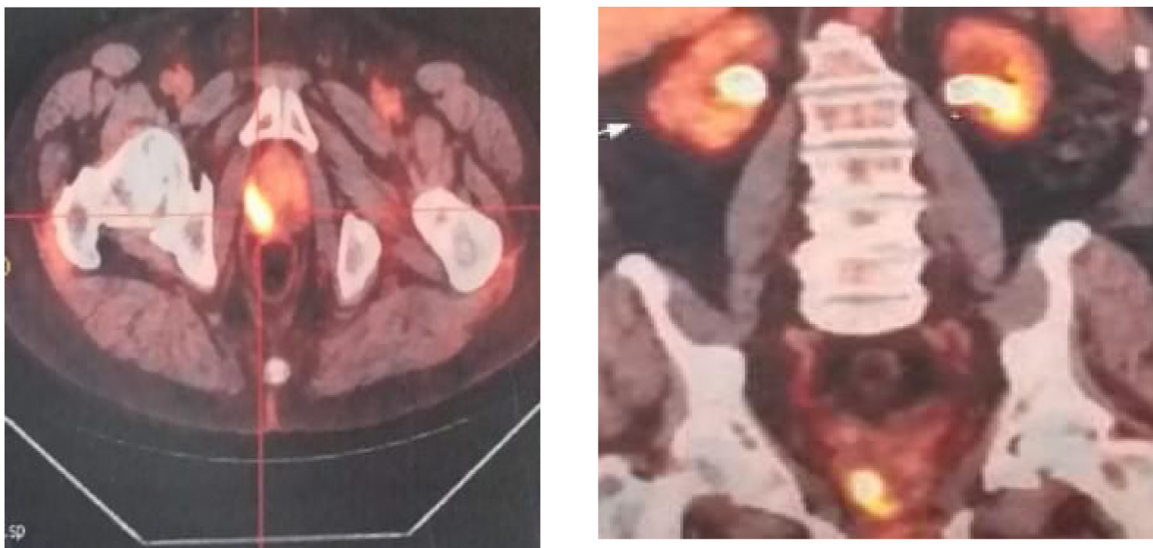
PET-CT 18-FDG a confirms a hypermetabolic focus of the right prostate lobe, with hypofixed irregularity of the right postero-lateral renal.
